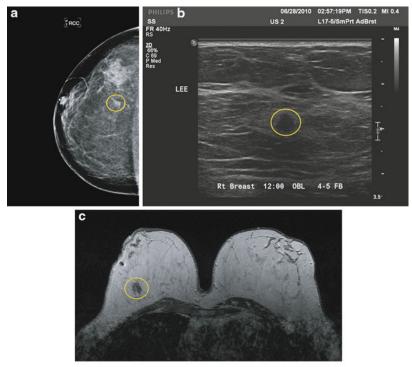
Breast cancer imaged by(a) mammogram,(b) ultrasound, and (c) MRI
